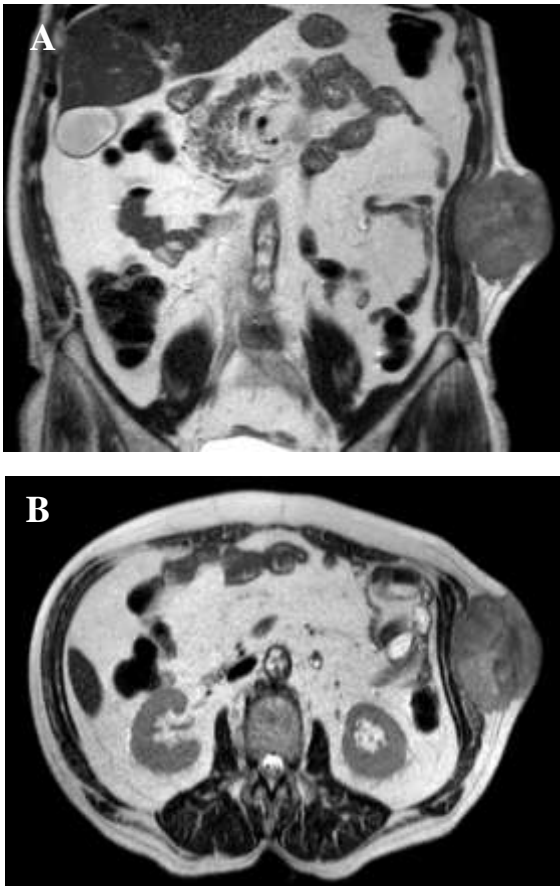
The abdominal MRI showing a mass with 85 × 75 mm in diameters. A. Axial view B. Transvers view
